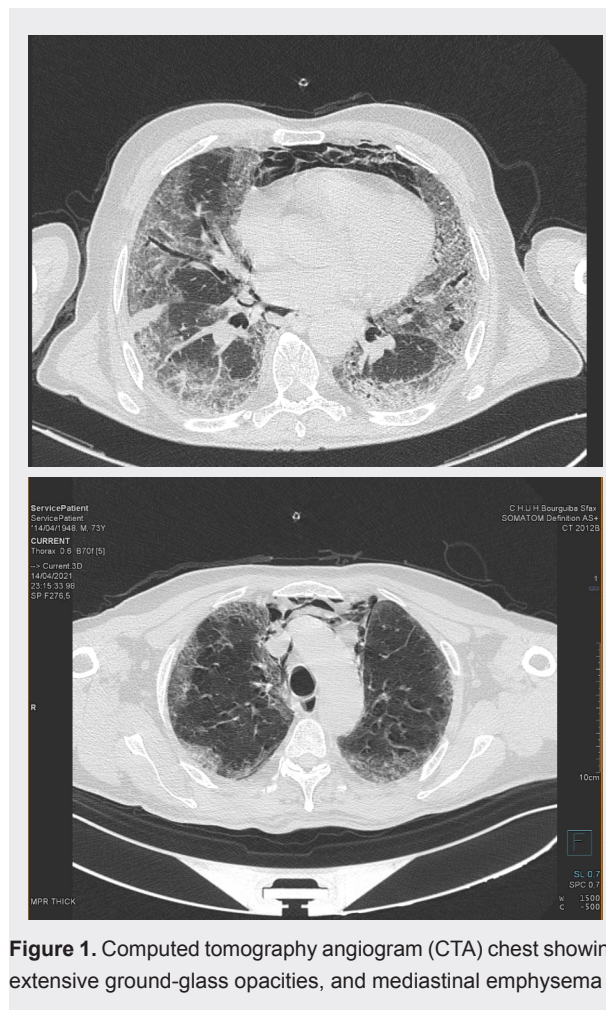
Computed tomography angiogram (CTA) chest showing extensive ground-glass opacities, and mediastinal emphysema
